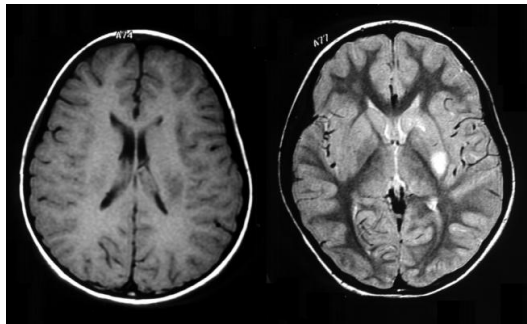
Example of a T2-MRI scan (right) and T1-MRI scan (left).
